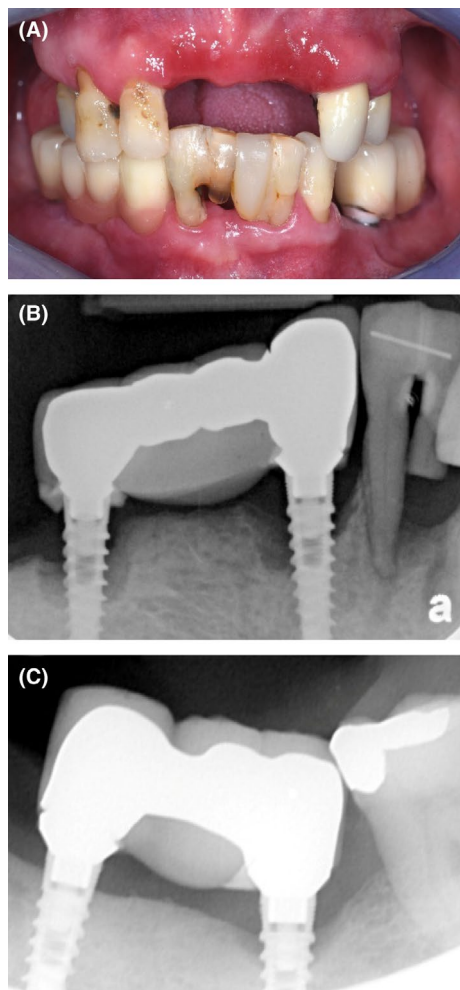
(A) Initial presentation of a patient referred for management of peri-implantitis. The patient had generalised periodontitis which had not been properly managed. (B) Periapical radiograph of implants in the mandibular right posterior segment, showing bone loss around both implants due to peri-implantitis. (C) Periapical radiograph of implants in the mandibular right posterior segment, showing bone loss due to peri-implantitis around the distal implant.
